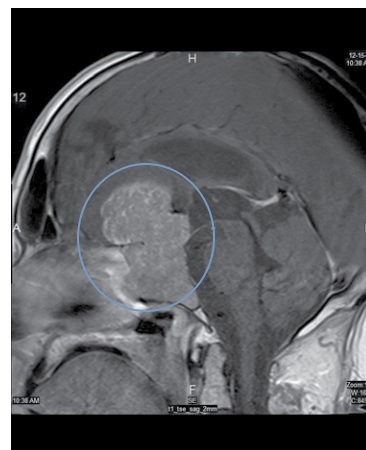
MRI/T1 (sagittal view) showing pituitary mass (suggestive of macroprolactinoma) with bony destruction and compression of optic chiasm.
